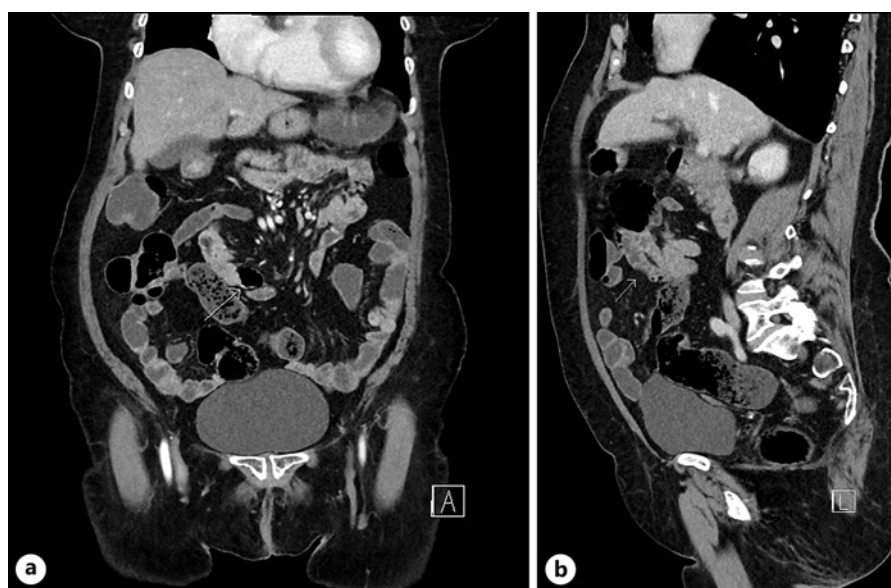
a Right paraduodenal internal hernia identified in abdominal computed tomography (arrow indicates diverticulum) – coronal plane. b Right paraduodenal internal hernia identified in abdominal computed tomography (arrow indicates herniated intestinal loop) – sagittal plane.
